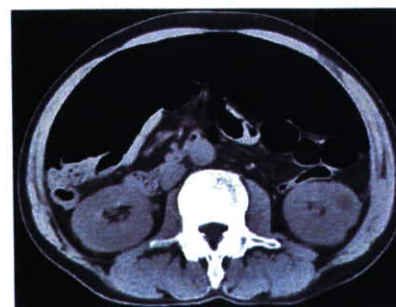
Abdominal CT scan showed severe pneumoperitoneum and compression of the inferior vena cava.
